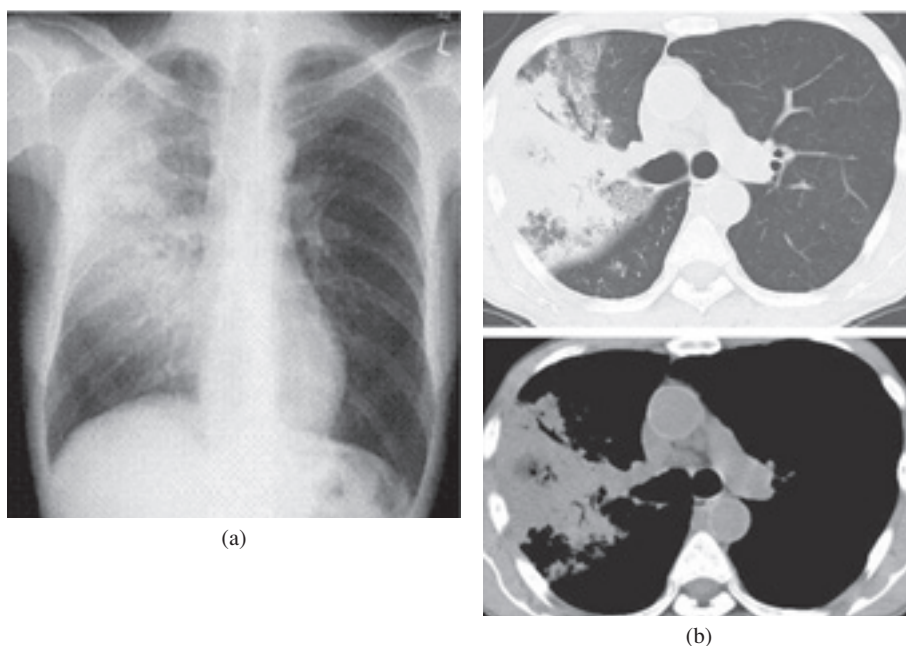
(a) Chest X-ray film on admission showing infiltrative shadows in the right upper and middle lung fields. (b) HRCT showing consolidation with air bronchogram in the right upper and middle lobes and patchy infiltrative shadows in the right S⁶. The mediastinal lymph nodes are slightly enlarged.
